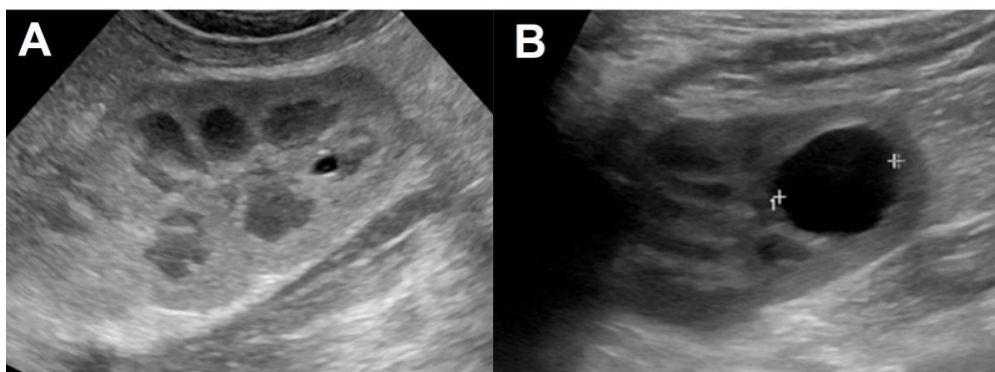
Kidney ultrasound shows renal cyst. (A) tiny right renal cyst was noted at 6 weeks of age. (B) Further increase in the size of the renal cyst was noted at 5 months of age ($d=1.46 \times 1.62$ cm).
